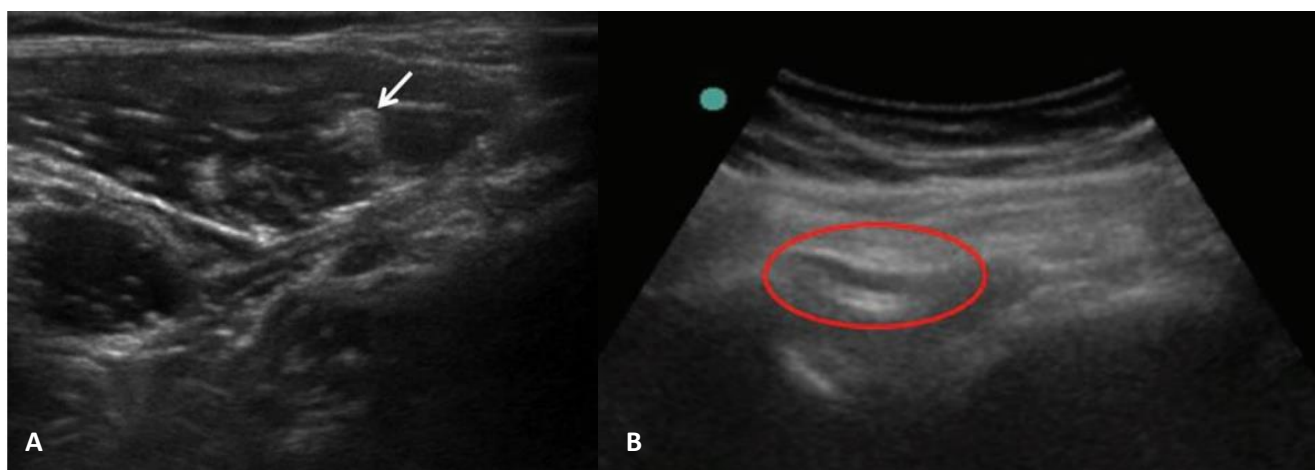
A) Ultrasound guiding femoral nerve (left), B) Ultrasound guiding sciatic nerve (right) ²
